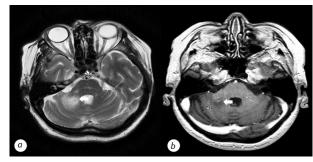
MRI scan results on 28.05. Lesions in the cerebellum peduncles have become more intense. There is an increase in edema in the right peduncle, with low signal intensity centrally in T1, indicating possible demyelination (white arrow). New multiple lesions in medulla oblongata have appeared, and trident sign can be seen in the pons: a-T2 axial FLAIR; b-T1 3D
